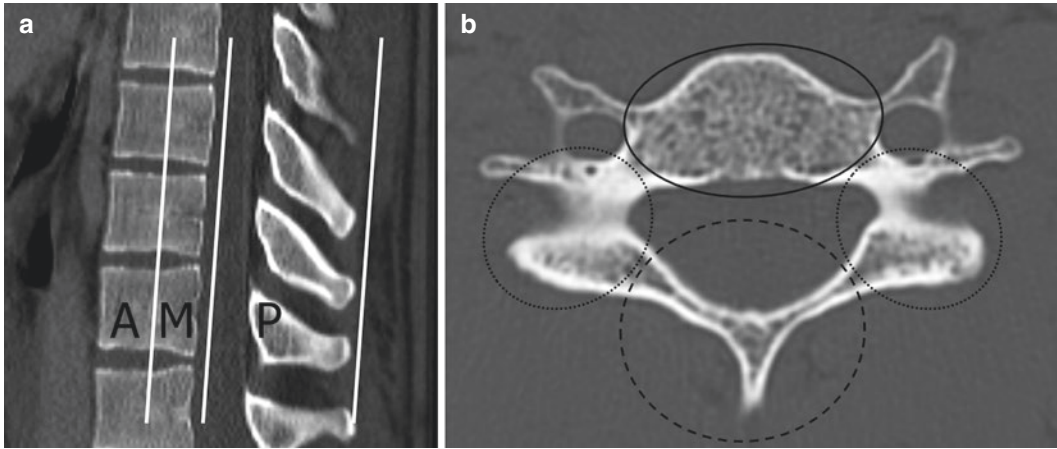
Potential of CT images in depicting the “three-column” model of Denis of the thoracic and lumbar spine (a), and the “four-column” model of the cervical spine (b). In the thoracic spine (a), a 2D-reformatted sagittal CT image shows the anterior column (A) formed by the anterior longitudinal ligament and the anterior (two-thirds) of the vertebral body and intervertebral disc, the middle column (M) formed by the posterior (one-third) of the vertebral body and intervertebral disc and posterior longitudinal ligament, and the posterior column (P) formed by the structures which are posterior to the posterior longitudinal ligament including pedicles, laminae, articular processes
